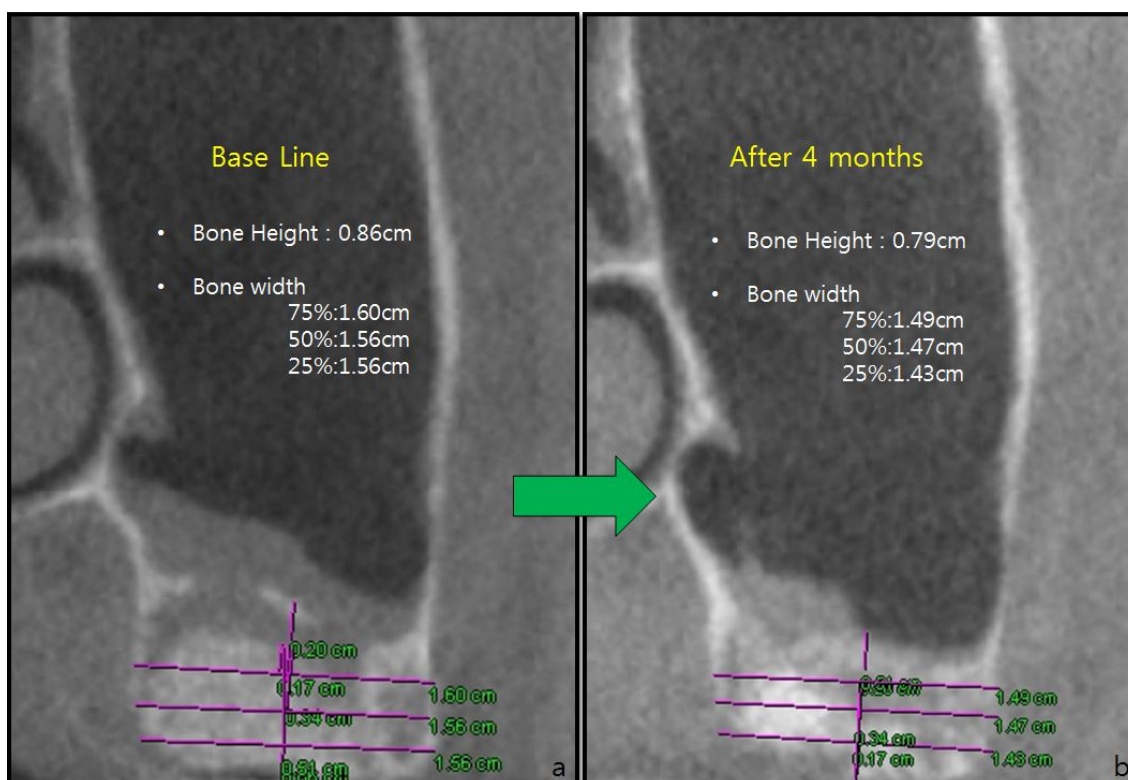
a)CBCT(Base line) b)CBCT(4 months after treatment)
